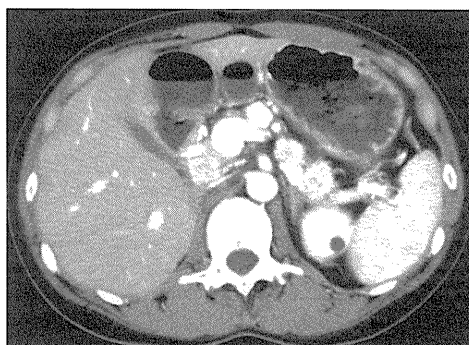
Contrast-enhanced abdominal computed tomography reveals several pancreatic mass lesions that are strongly enhanced (33-year-old female)^[14].
